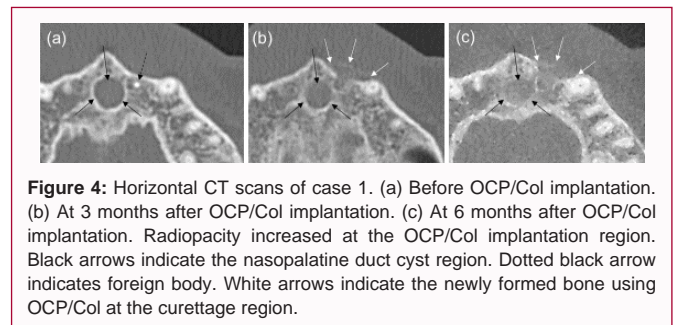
Horizontal CT scans of case 1. (a) Before OCP/Col implantation. (b) At 3 months after OCP/Col implantation. (c) At 6 months after OCP/Col implantation. Radiopacity increased at the OCP/Col implantation region. Black arrows indicate the nasopalatine duct cyst region. Dotted black arrow indicates foreign body. White arrows indicate the newly formed bone using OCP/Col at the curettage region.
